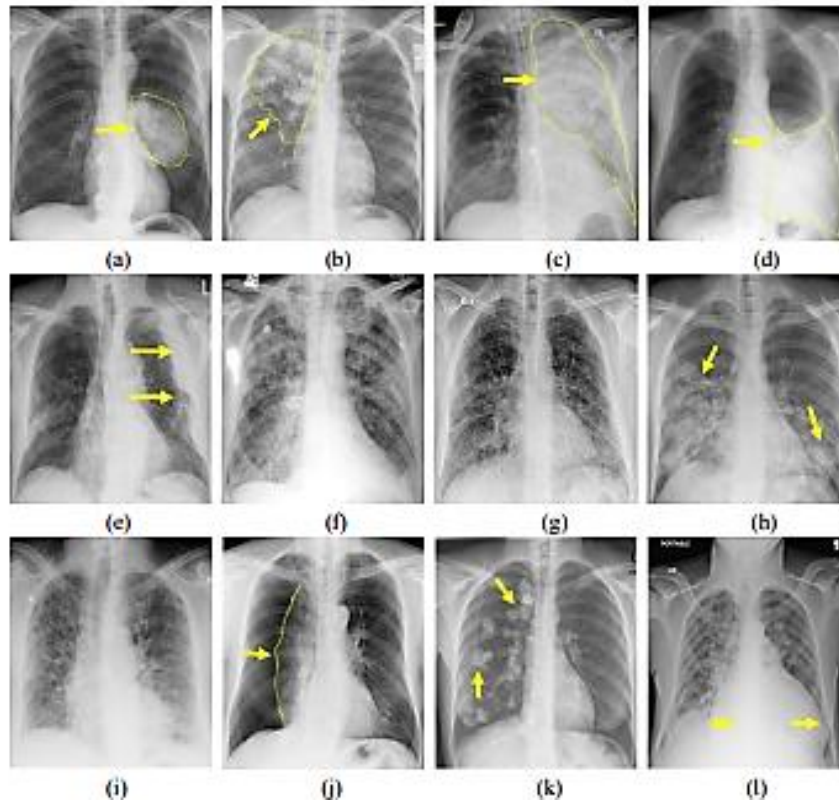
Chest X-Ray images showing radiographic responses of (a) Lung Cancer (b) Tuberculosis (c) Pneumonia (d) Pleural Effusion (e) Pleural Thickening (f) Pulmonary Edema (g) Pulmonary fibrosis (h) Pulmonary Infiltrate (i) Pulmonary Fibrosis (j) Lung Collapse (k) Lung Nodules (l) Cardiomegaly.
